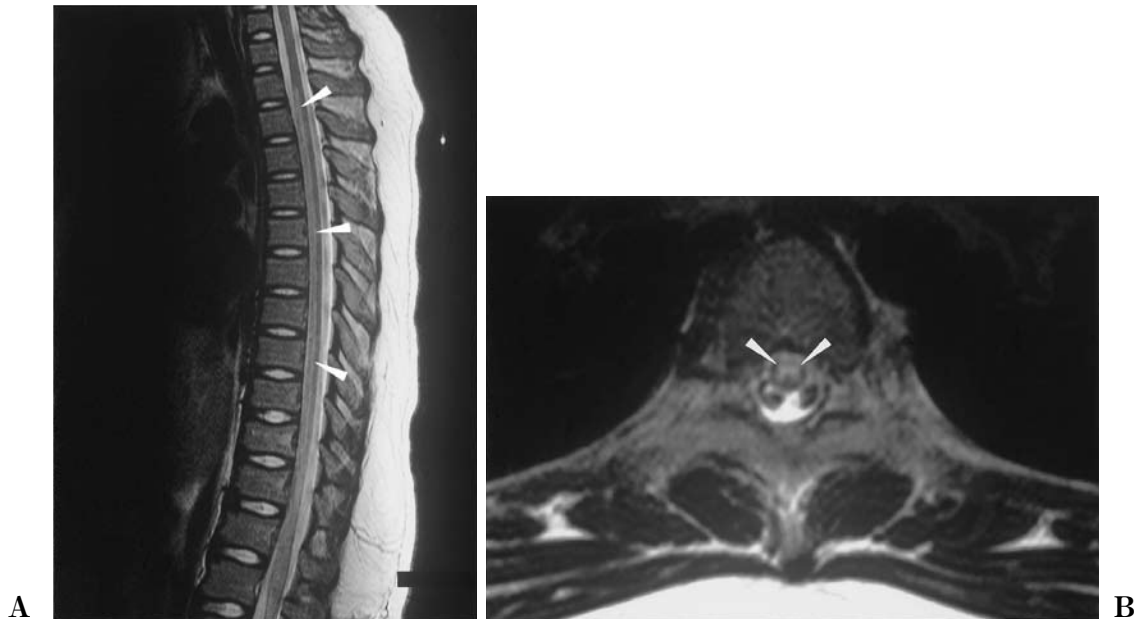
Spinal Magnetic Resonance Imaging
